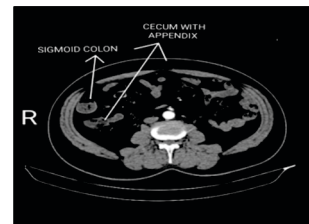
An Axial Slice of CT Showing Sigmoid Colon on Right Side in Anterior Relation to the Cecum and Appendix.
